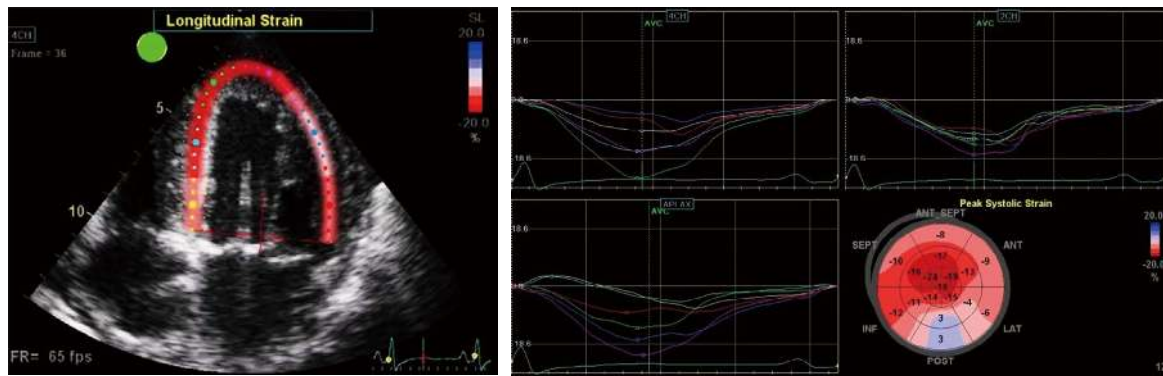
Myocardial strain echocardiography in an 84-year-old male patient with acute heart failure. (Left) Speckle-tracking analysis in the apical 4-chamber view. (Right) Longitudinal strain curves in all left ventricular segments. Peak systolic strains shown on the polar map are markedly decreased in the posterolateral segments. GLS was -12.4% .
